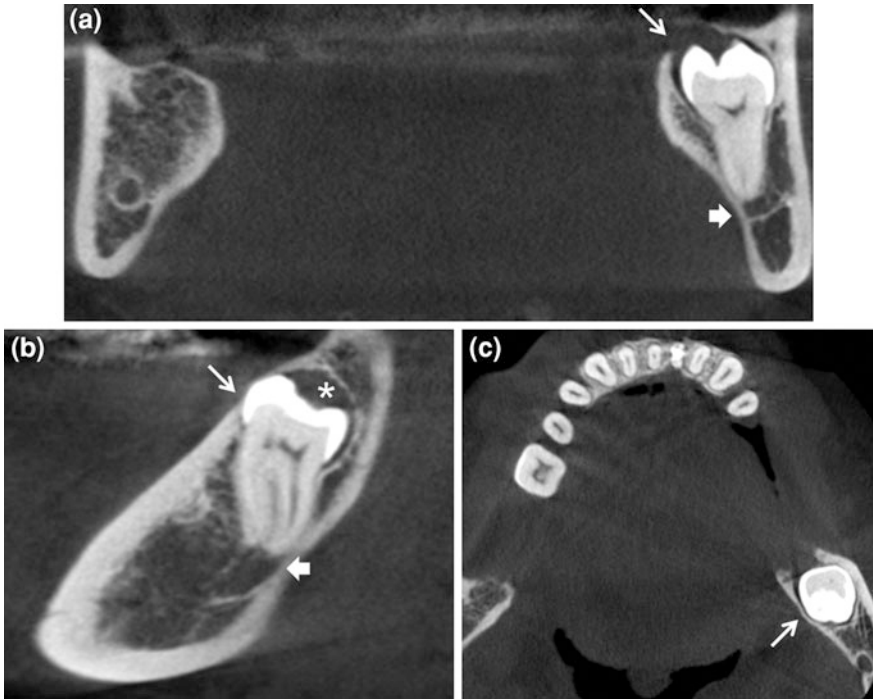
CBCT coronal (a), sagittal (b) and axial (c) scans showing the left mandibular third molar that is vertically impacted (*thin arrow*). Note the mild enlargement of follicular space (*) (radiopaque layer around the crown). Impacted 38 is in relation with the superior wall of the mandibular canal (*arrow*)
